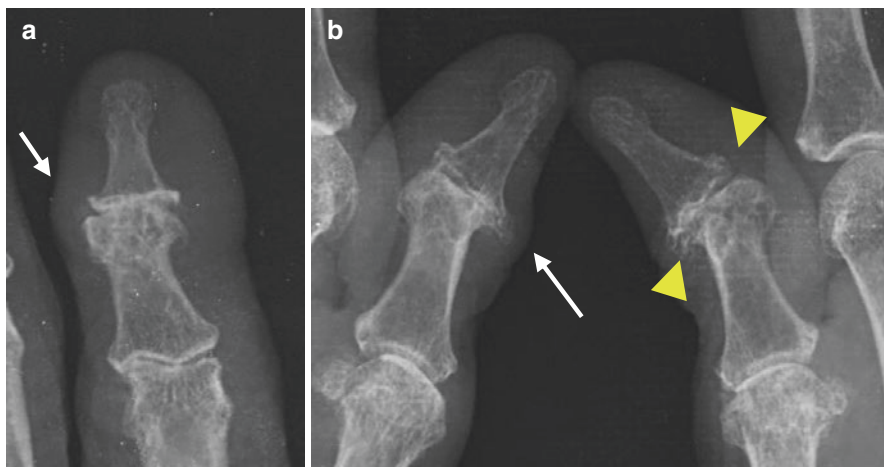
Radiographic findings in erosive osteoarthritis – hands
